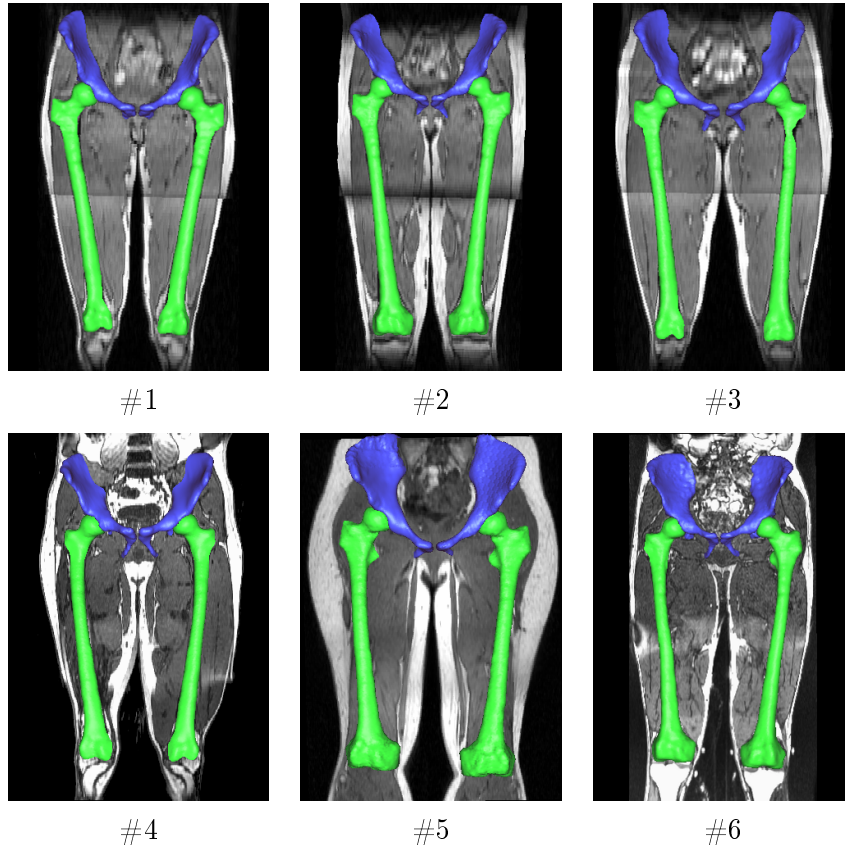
The six datasets that are used for the experiments with their MR image and corresponding reference meshes (*i.e.* hip bones in blue and femur bones in green). The three datasets on the top constitute the D3 training set while all datasets together constitute the D6 training set. Note how rather linear is the intensity distribution between datasets of D3. Conversely, the three datasets on the bottom feature a quite heterogeneous intensity distribution. Among them, dataset #4 and dataset #6 are strongly subject to MRI artifacts.
